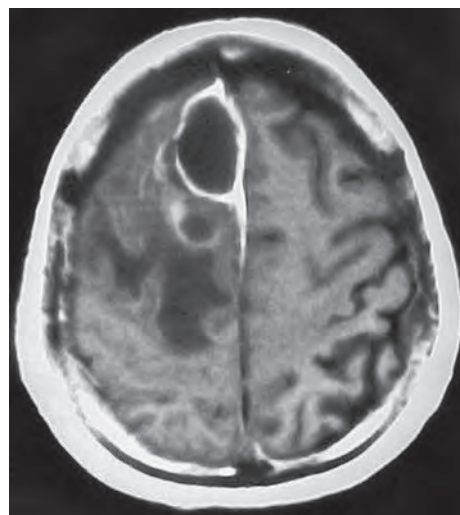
MRI axial view showing right parafalcine cystic tuberculoma
